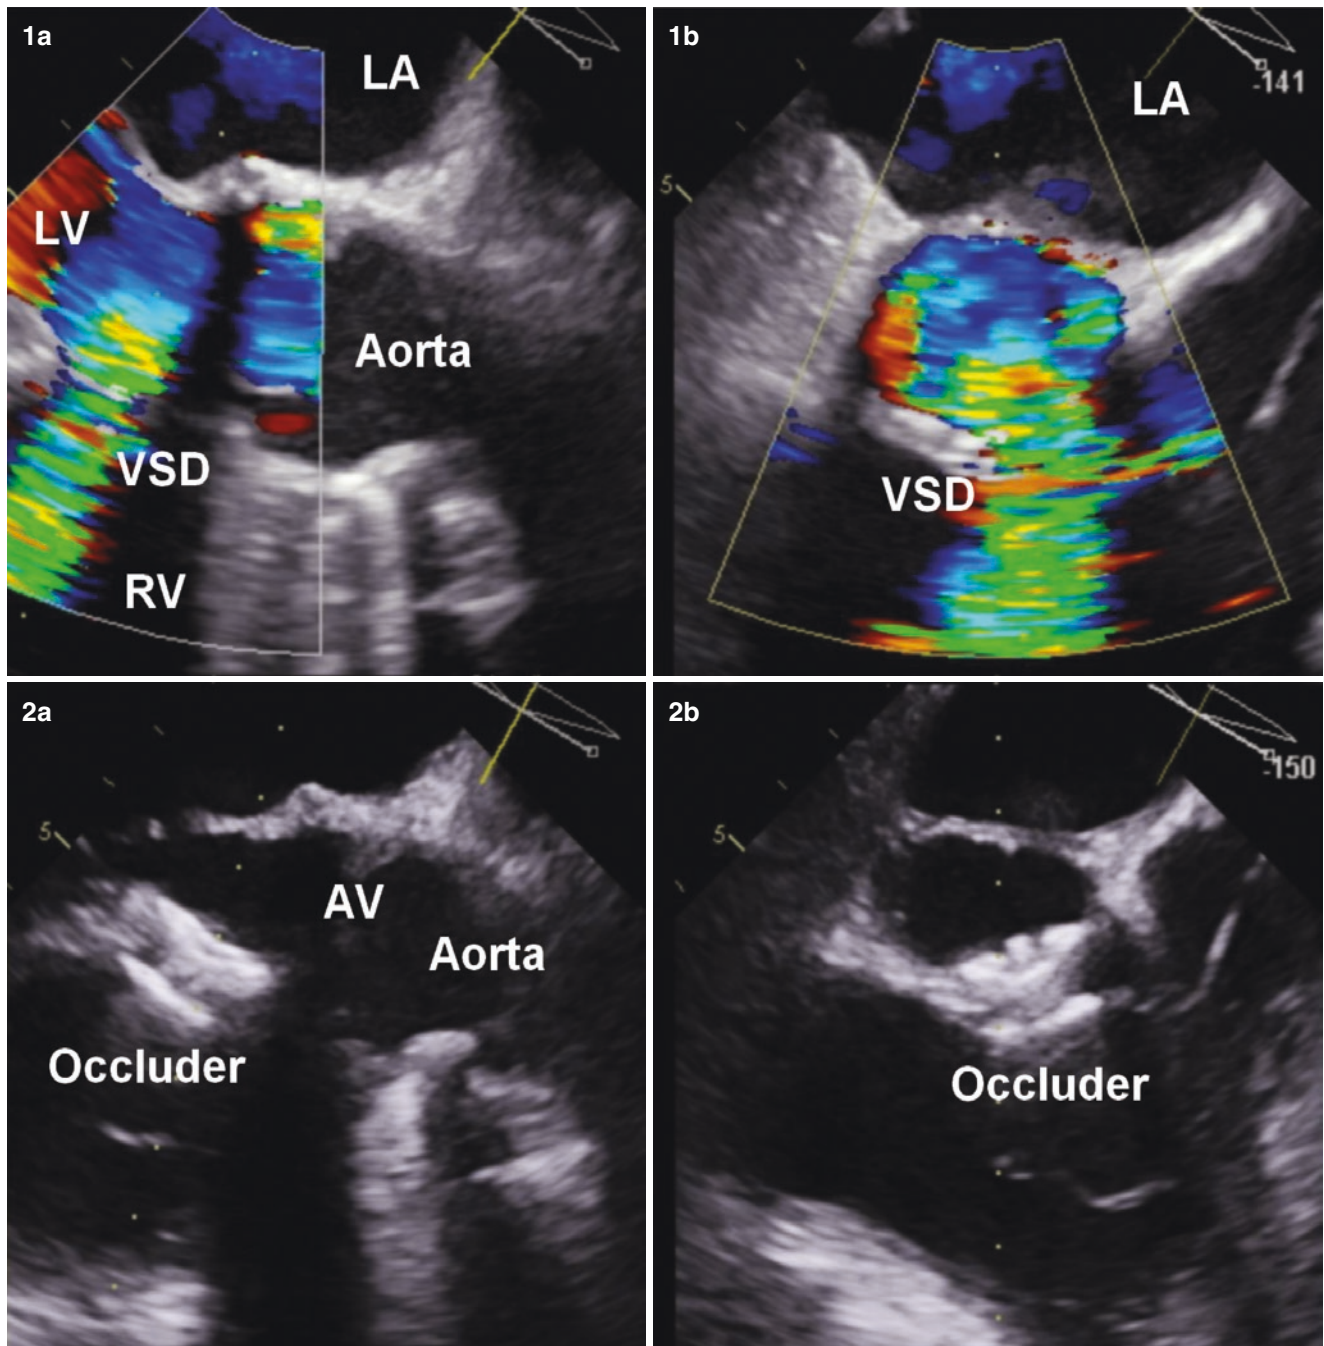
Example of postsurgical muscular VSD closure. Transesophageal echocardiography of a postsurgical muscular VSD in a 73-year-old male after recurrent aortic valve surgery and myectomy (Qp/Qs ratio 2, evidence of pulmonary hypertension, 1a) color Doppler long axis and 1b) short axis view visualizing the defect). A maximum
